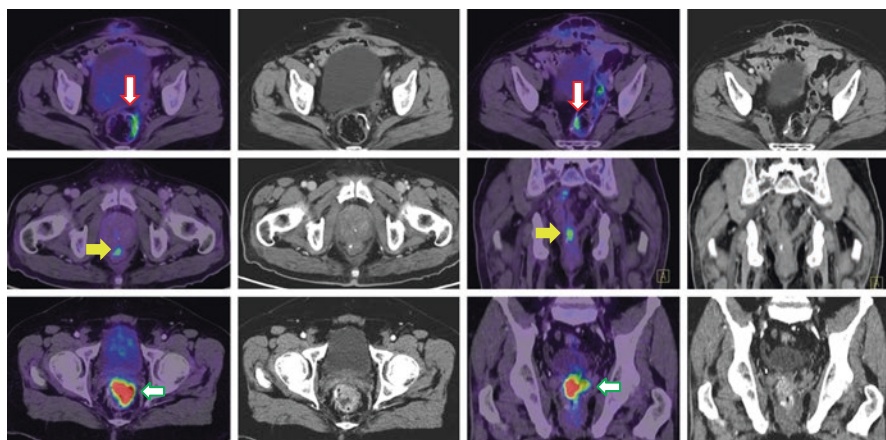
Anastomotic site FDG uptake interpretation: Upper row images—FDG PET/CT scan done 4 weeks after surgery for restaging shows post-surgical inflammation (*red arrow*) with no abnormal wall thickening at the anastomotic site. Middle row images—FDG PET/CT scan done 2 years after surgery in a patient with rising CEA levels. Mild FDG uptake is noted at the anastomotic site with doubtful thickening (*yellow arrow*). Colonoscopy is suggested for further evaluation of the anastomotic site. Lower row images: FDG PET/CT scan done 1.5 years after surgery showing intensely FDG-concentrating definitive lesion at the anastomotic site (*green arrow*)
